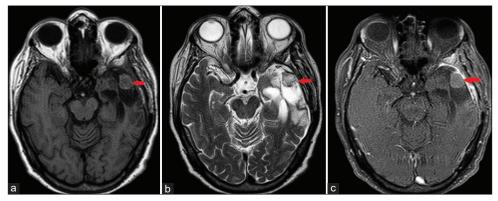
(a-c) Control magnetic resonance imaging after two cycles of combined chemotherapy: left pterional craniotomy with extra-axial residual surgical hemostatic material (red arrows). Extensive parenchymal left temporal resection with extension into the frontal and parietal lobes. No contrast-enhancing lesion or midline shift.
